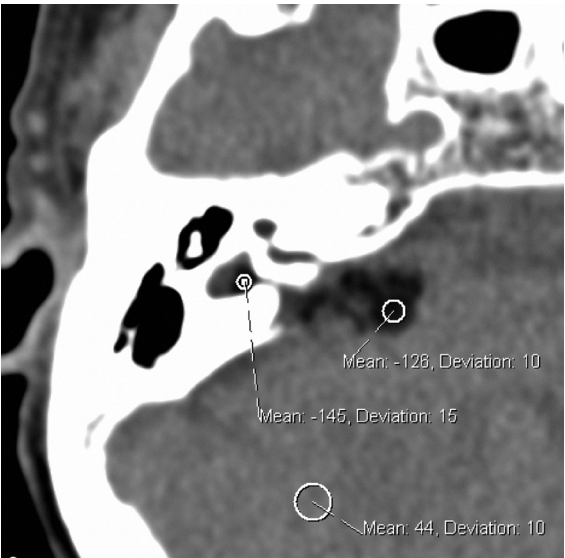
Axial computed tomographic image of the right inner ear, soft tissue window. Hounsfield attenuation unit (HU) measurements performed of the lesion in the vestibule and cerebellopontine angle show densities corresponding to fat (normally, -50 to -150 HU) (small, medium, and large statistics circles indicate mean [SD] measurements of -145 [15], -126 [10], and 44 [10] HU, respectively). For comparison, densitometry was performed of cerebellar brain tissue as well (large statistics circle), showing densities corresponding to brain tissue (>40 HU).
